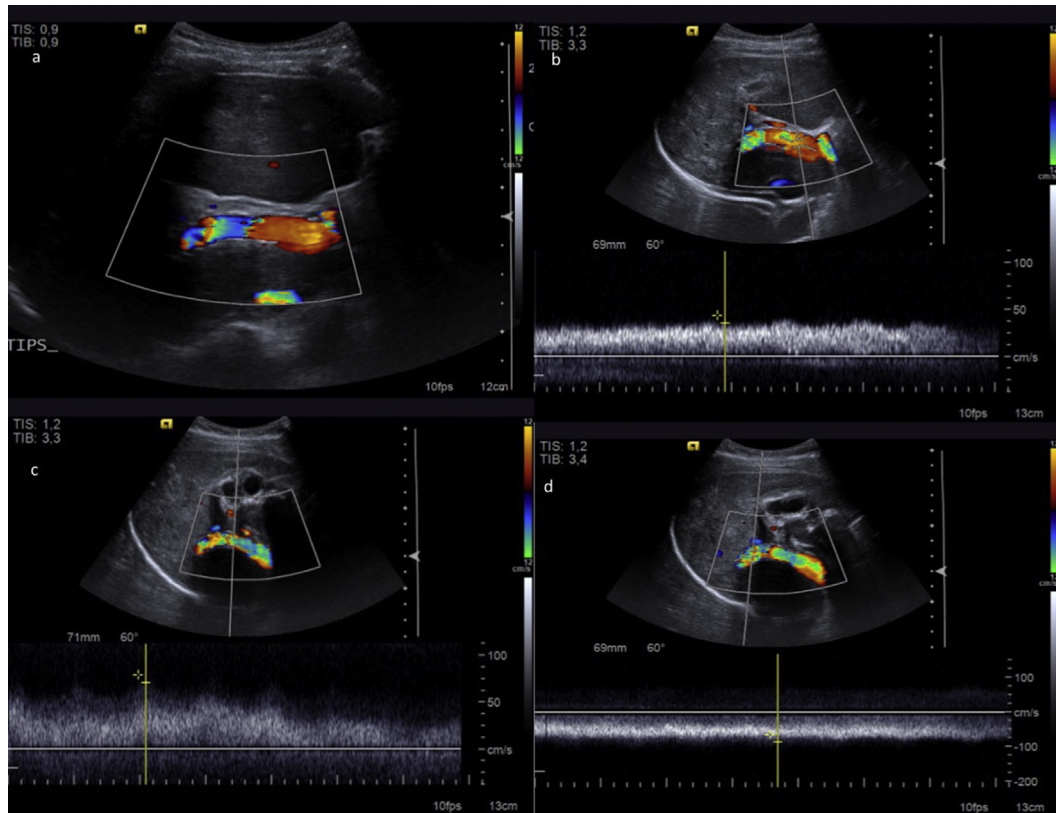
Liver Color-Doppler US (A–D). A, Color-Doppler US showed the normal positioning of the device between the right portal vein and the right suprahepatic vein. B–D, normal functioning of the TIPS device was apparent from the anterograde and hepatopetal flow through it from the caudal to middle and finally to cephalic portions.
